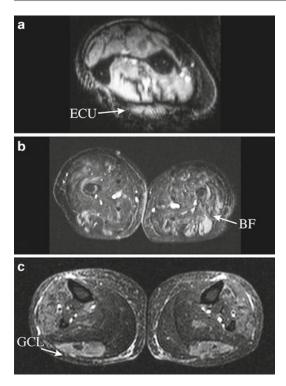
Axial fat-suppressed T2-weighted MRI (short tau inversion recovery, STIR) scans of patients with inclusion body myositis. (a) Edema in the right extensor carpi ulnaris muscle (*ECU*). (b) Edema in the biceps femoris muscle (*BF*). (c) Edema in the lateral head of the gastrocnemius muscle (*GCL*). Corresponding T1-weighted images are shown in Fig. 26.7c
